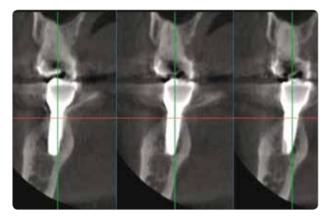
Delivery prosthesis CT
